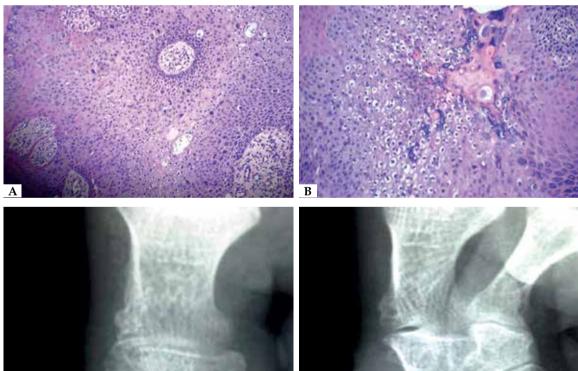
A) APX-ray: No bone involvement; B) X-ray Profile: No bone involvement
